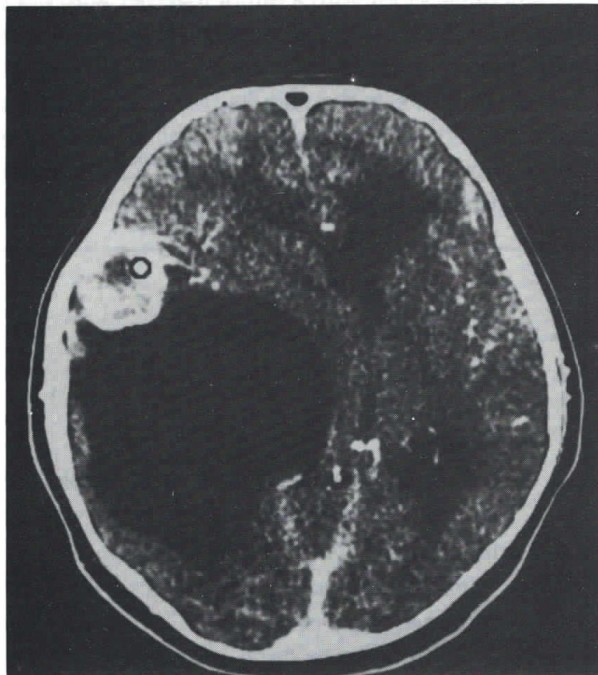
(Case 1) Postcontrast CT scan showing a contrast enhancing subcortical nodule.
